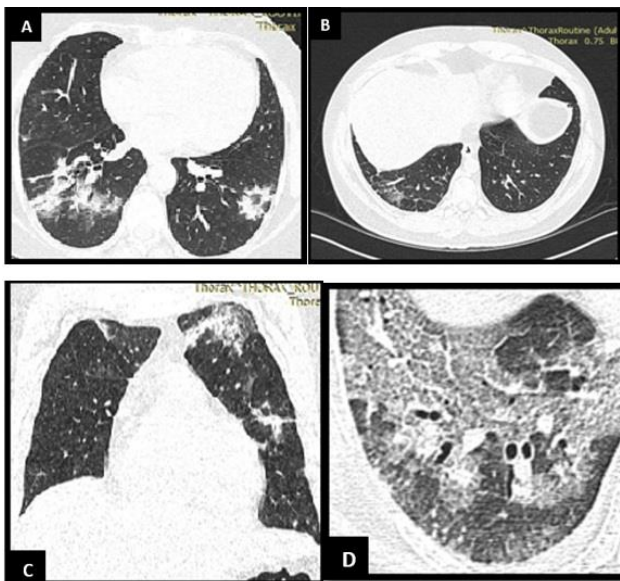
Different radiological patterns of organizing pneumonia on chest computed tomography scan: Multifocal parenchyma condensations (A), frosted glass hyperdensity (B), arciform condensations (C), and crazy paving (D)
